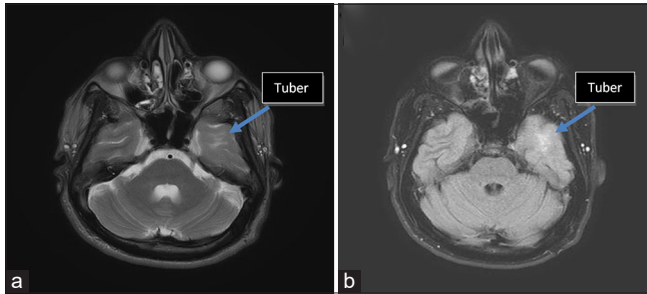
MRI brain - Axial T2 (a) and fluid-attenuated inversion recovery (b) images show ill-defined hyperintense lesions in the subcortical region of the left temporal lobe representing “tubers.”
